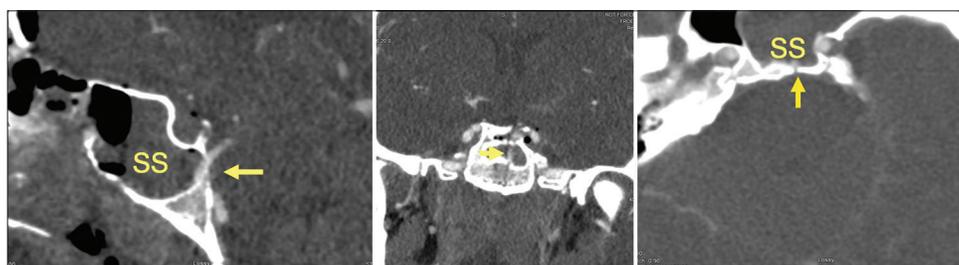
CT angiography of the head with sagittal, coronal, and axial views, respectively, from left to right. Sphenoid sinus (SS) and arrows identify the basilar artery encased within the fracture line within the sphenoid sinus.
